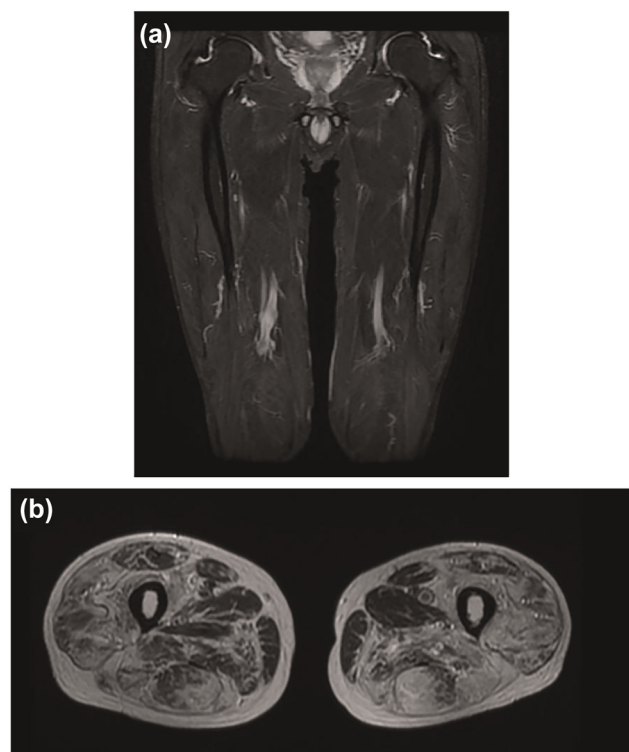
The thigh MRI scan of the patient. (a) STIR and (b) T2 both revealed extensively moderate to severe fatty infiltration and atroph, with the sartorius, gracilis, and adductor longus muscles being relatively spared.
